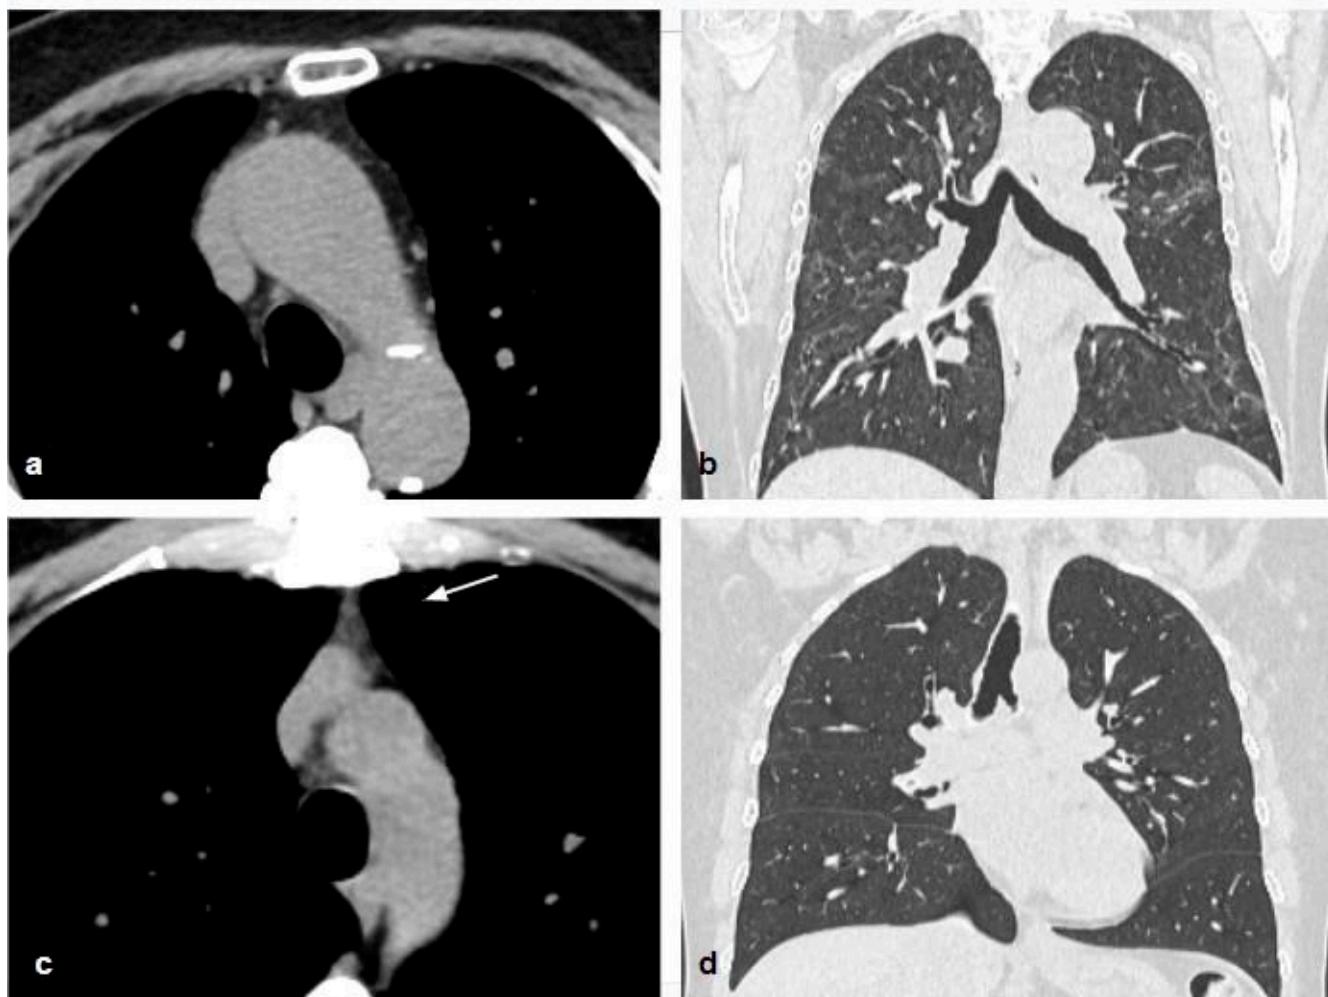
Follow-up unenhanced chest CT images of a 64-year-old (panels a,b) and a 65-year-old (panels c,d) male patient. The first patient had a complete fat involution of the thymus on the mediastinal window (a); coronal multiplanar reconstruction with lung parenchymal window shows bilateral persistence of ground-glass opacities involving <50% of pulmonary parenchyma (b). The second patient showed a well-identifiable thymus with partial fat involution (c), without any sign of parenchymal sequelae (d).
